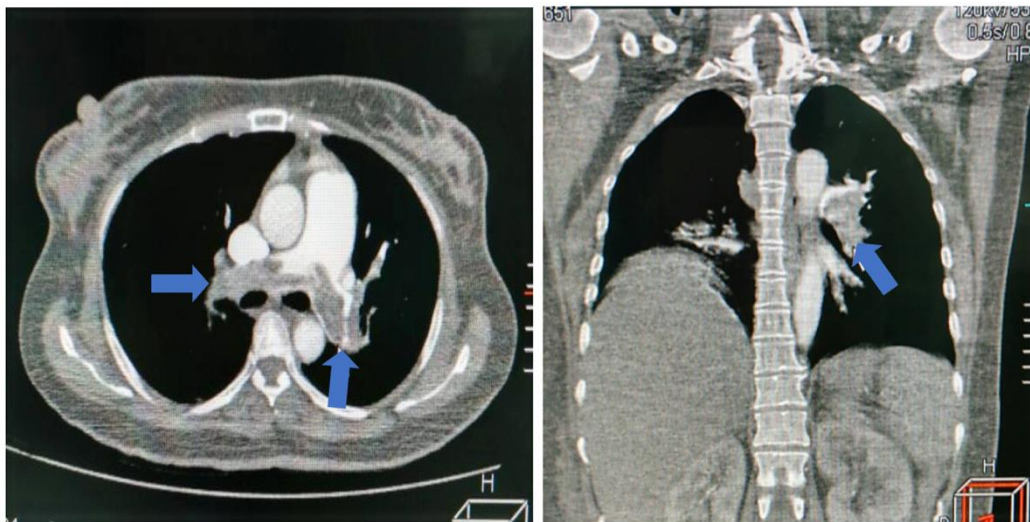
CT Pulmonary Angiography (CTPA) in Emergency Room. Left: Axial view, thrombus (filling defect) was seen in the right and left pulmonary arteries (blue arrow); Right: Coronal view, a thrombus (filling defect) was seen in the left pulmonary artery (blue arrow).
